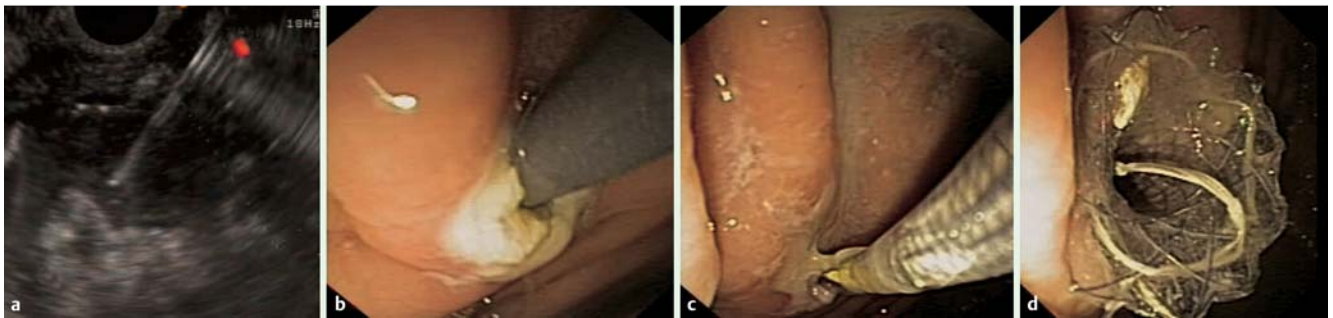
a Endoscopic ultrasound-guided puncture in a 53-year-old man with a pancreatic pseudocyst. b Fistula created by pre-cut. c A covered self-expandable metal stent (CSEMS) on the guide wire. d The CSEMS observed from the stomach.
